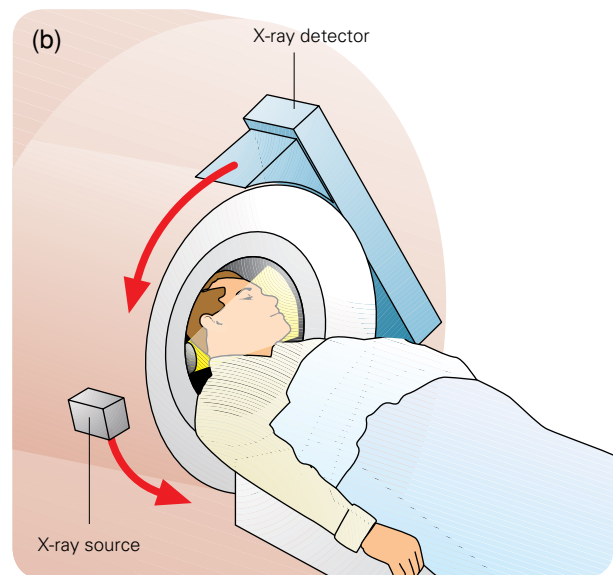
(a) A CT scanner. (b) A CT scan is produced by a computer that compiles a series of different X-ray images taken from different angles around the head. (c) A horizontal plane is a cross-section of the brain shown in a CT scan.
